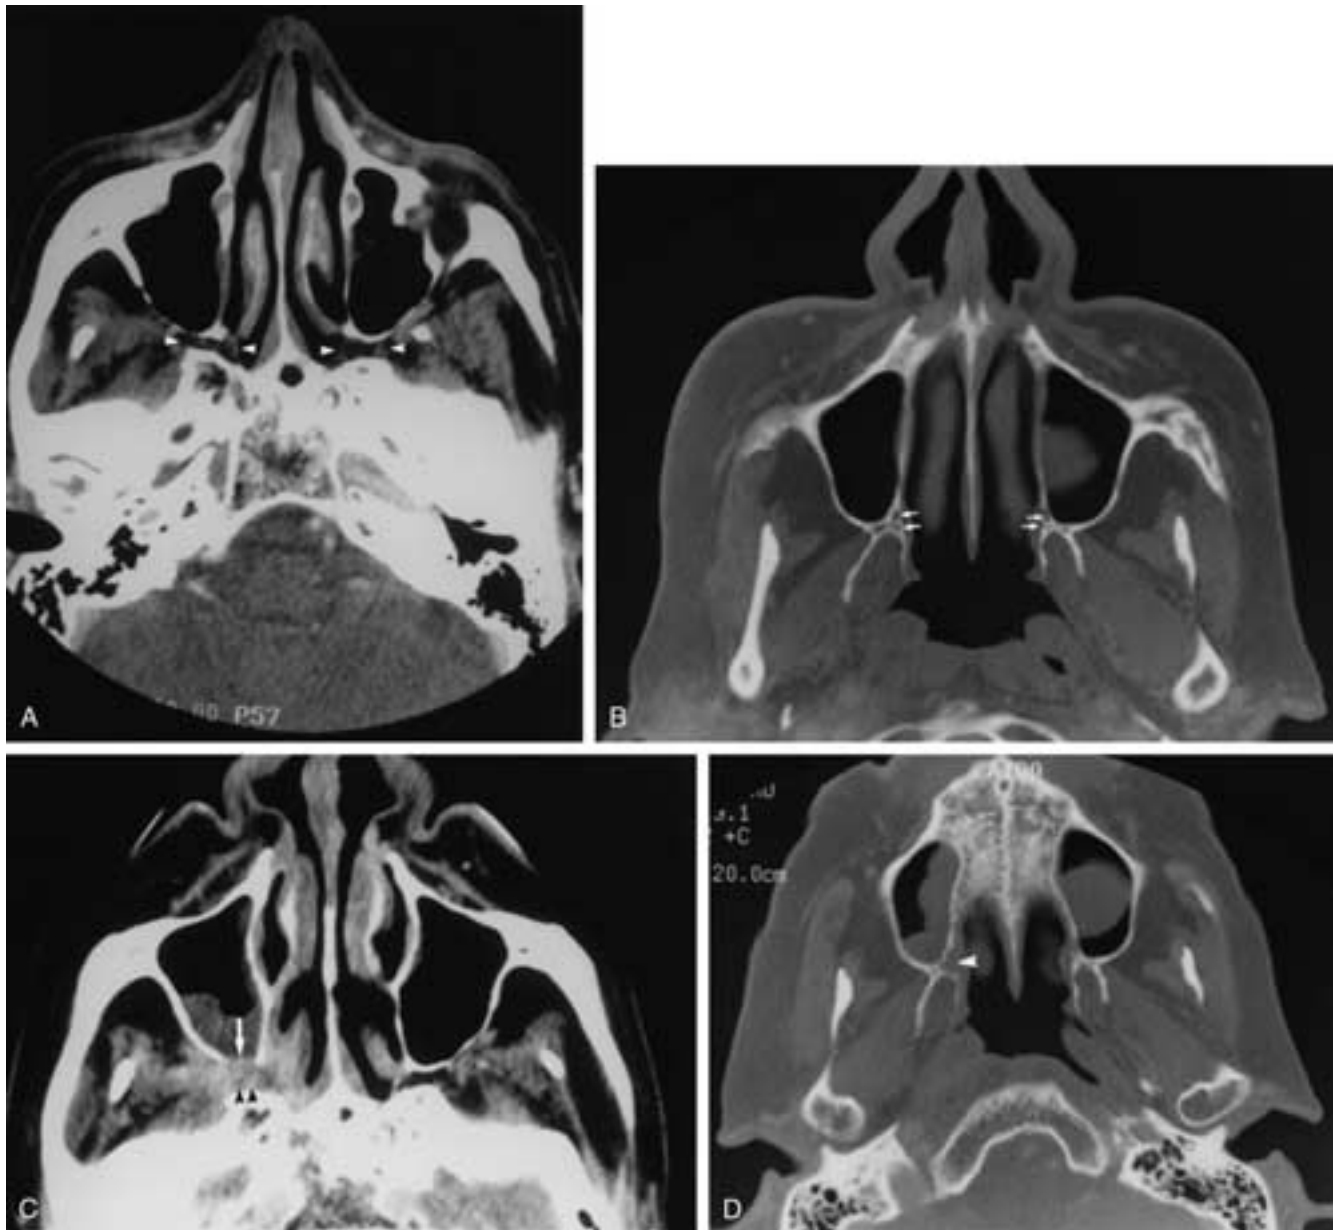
Squamous cell carcinoma of the right soft palate with development of perineural spread along the palatine nerves. Axial contrast-enhanced soft-tissue (A) and bone window (B) CT scans at the time of diagnosis of the palate lesion. The PPFs (arrowheads) are normal. On the bone window images through the pterygoid plates, the palatine foramina are normal (arrows). The palatine branches of V_2 traverse these foramina en route to/from the palate and PPF. Axial contrast-enhanced soft-tissue (C) and bone window (D) CT scans at levels similar to those of A and B obtained 3 months later. There is abnormal widening and enhancement representing PNS within the right PPF (arrowheads). The posterior wall of the right maxillary sinus is destroyed (arrow). On the bone windows, the right palatine foramina are now destroyed (arrowhead). Compare with B. (From Ginsberg LE, DeMonte F. Imaging of perineural tumor spread from palatal carcinoma. AJNR 1998;19: 1417–1422.)
